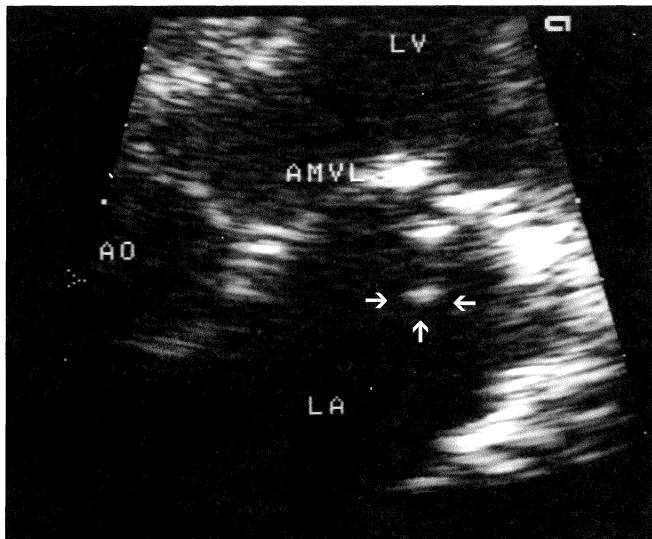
Transthoracic echocardiogram showing a vegetation (arrows) on the atrial aspect of the anterior mitral valve leaflet. (LV=left ventricle, LA=left atrium, AMVL=anterior mitral valve leaflet, AO=aorta)
